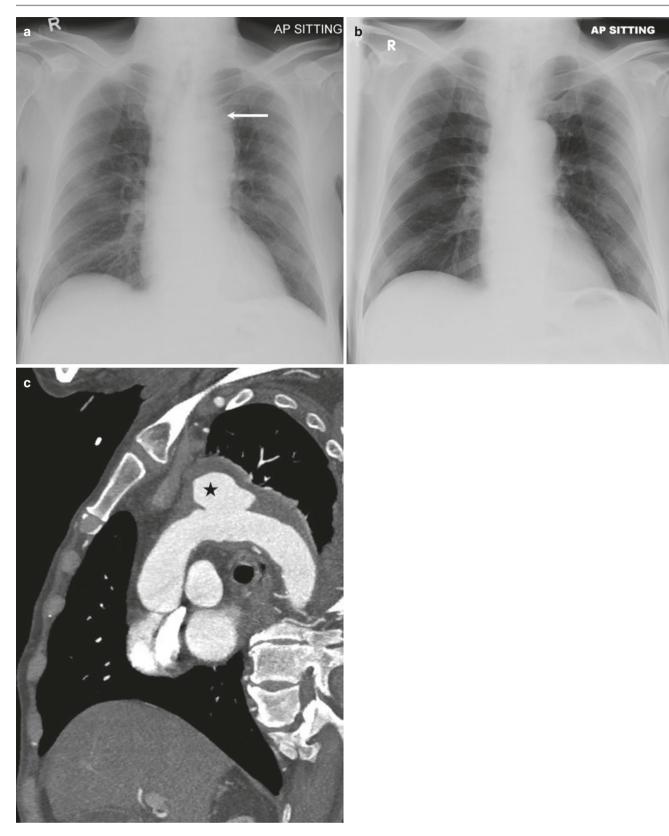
80-year-old man presented with shortness of breath in the emergency department. (a) AP chest radiograph shows silhouetting of the superior border of aortic arch by an ill-defined opacity (arrow), a
